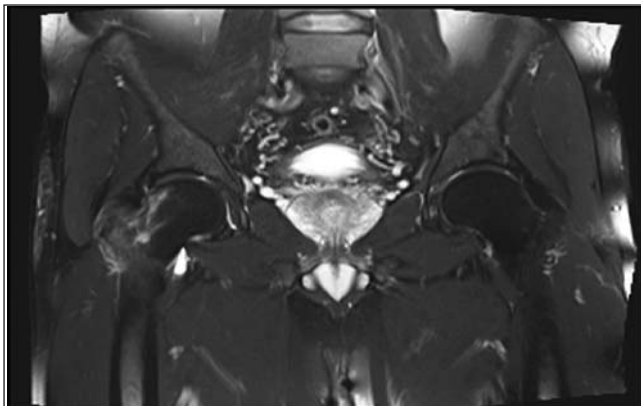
MR image of the patient with stage 2 avascular necrosis in the right femur head.
